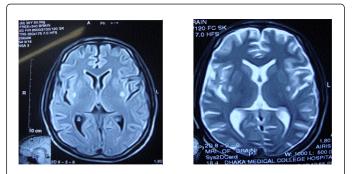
MRI of brain showing features of toxic encephalopathy.
